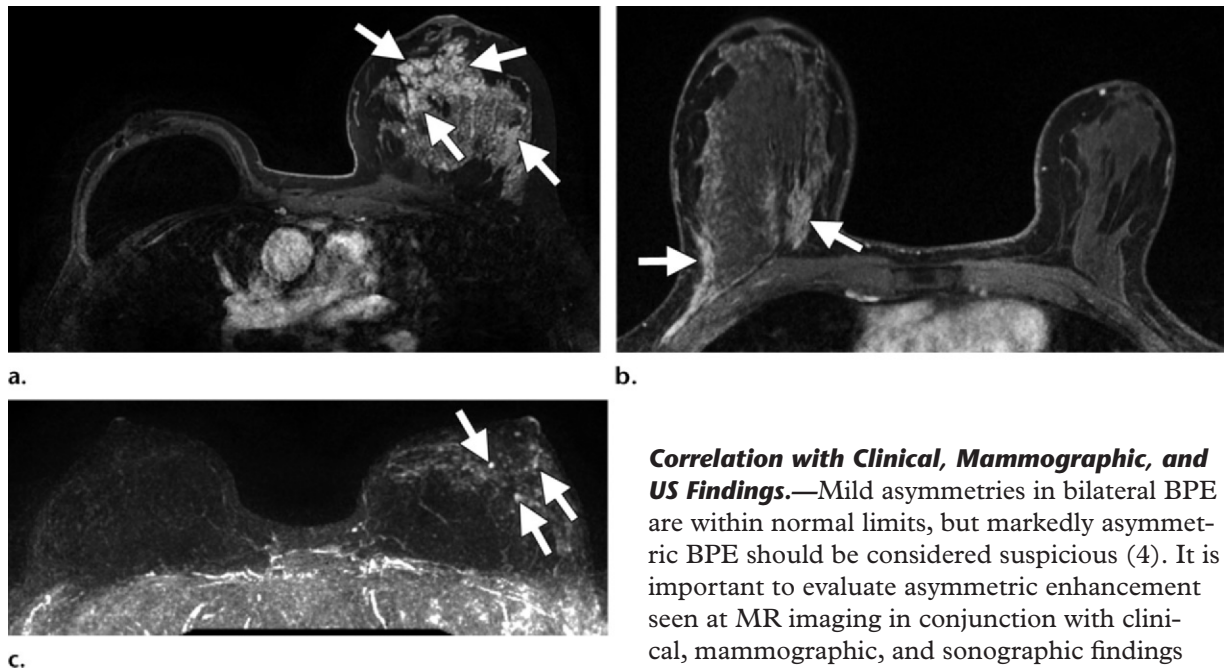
Various patterns of BPE in the untreated breast of three different young premenopausal women with previously treated breast cancer. (a) Axial contrast-enhanced T1-weighted fat-suppressed MR image of a 34-year-old woman with previous right ductal carcinoma in situ in 2003 that was treated with breast conservation therapy and radiation therapy and a recurrence in 2006 that was treated with right mastectomy shows marked diffuse BPE (arrows) in the untreated left breast. (b) Axial contrast-enhanced T1-weighted fat-suppressed MR image of a 37-year-old woman with previous invasive cancer in the left breast in 2004 that was treated with lumpectomy and radiation therapy shows picture framing (arrows) in the lateral and medial portions of the untreated right breast. (c) Maximum intensity projection image of a 37-year-old woman with previous right ductal carcinoma in situ that was treated with lumpectomy and radiation therapy in 2007 shows stippled BPE (arrows) in the untreated left breast.
